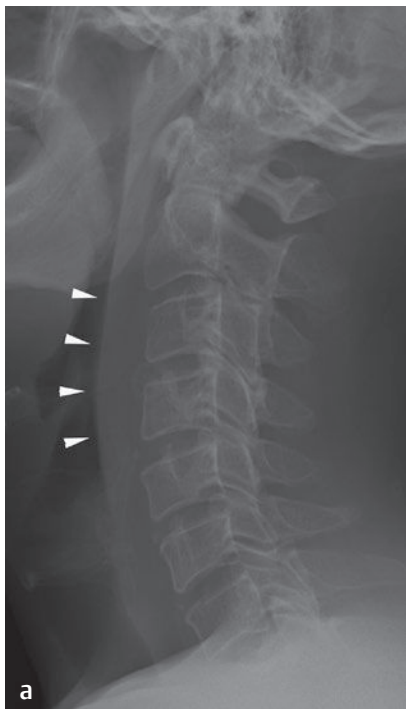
Extension-distraction injury with incomplete spinal cord injury in a 35-year-old man who was injured in a fall from a scaffold, with forcible extension of the neck. (a) A lateral radiograph shows substantial edema in the anterior soft tissues (*arrowheads*). (b) A sagittal reconstructed CT scan shows avulsion from the C4 inferior end plate (*arrow*). (c) A sagittal T2-weighted image shows the acute tensile failure of the C4-C5 disc, with bright signal within the disc (*arrow*); anterior soft-tissue edema also is visible (*arrowheads*). The patient was treated nonsurgically because of the absence of severe instability or cord compression. (From Khanna AJ, Kwon BK. Subaxial cervical spine injuries. In: Rao RD, Smuck M, eds. Orthopaedic Knowledge Update: Spine 4. 4th ed. Rosemont, IL: American Academy of Orthopaedic Surgeons, 2012:221–233. Reprinted by permission.)
